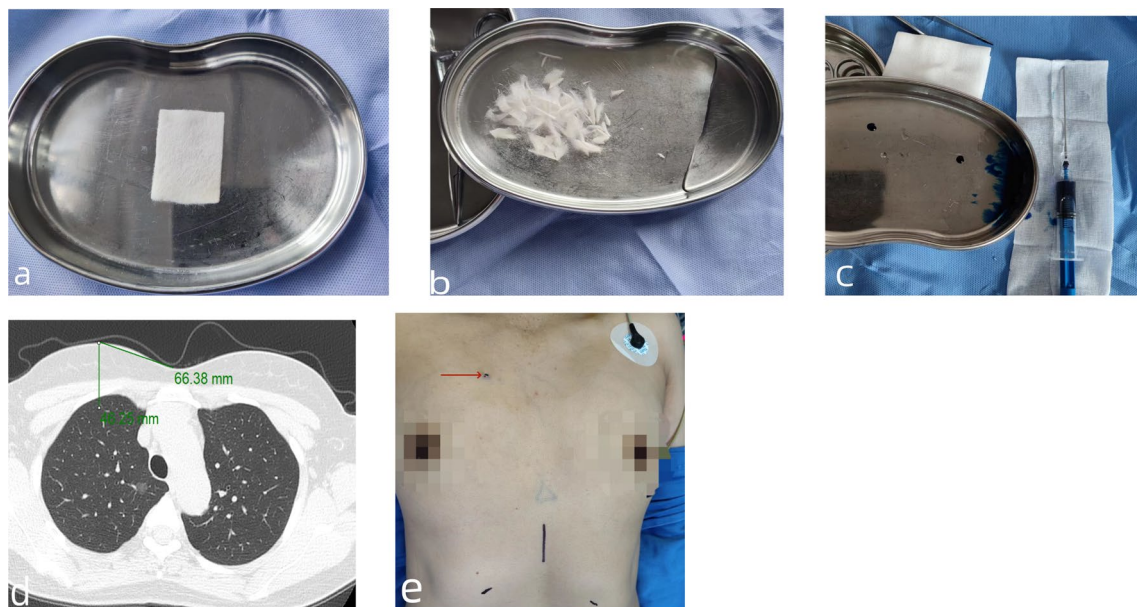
a Absorbable hemostatic materials, b the absorbable hemostatic material was cut into small pieces and dissolved in glucose solution, c that methylene blue solution was added and mix well, d the measurement of puncture depth of the puncture needle from CT images, e the selection of puncture points
